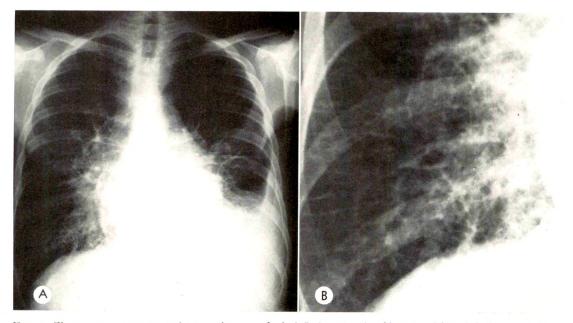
Chest roentgenogram taken at the age of 16. (A) A network of increased interlobular septa is seen throughout the lung fields. They are more prominent near the hili and represent (based on the biopsy) fibrotic septa containing enlarged vascular spaces. A close-up view (B) shows the markings in detail. The left hemothorax is due to the exploratory thoracotomy and was resorbed in a few days.
